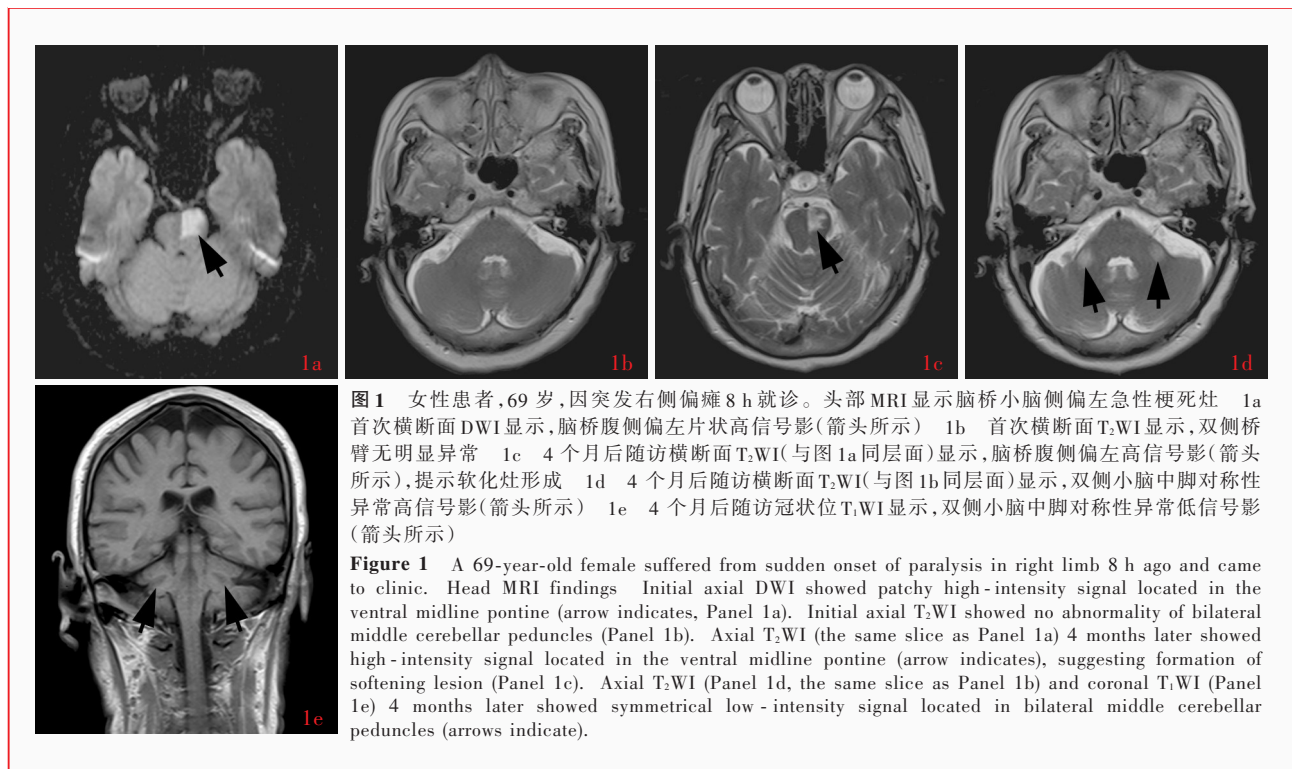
女性患者,69 岁,因突发右侧偏瘫 8 h 就诊。头部 MRI 显示脑桥小脑侧偏左急性梗死灶 1a 首次横断面 DWI 显示,脑桥腹侧偏左片状高信号影(箭头所示) 1b 首次横断面 T₂WI 显示,双侧桥臂无明显异常 1c 4 个月后随访横断面 T₂WI(与图 1a 同层面)显示,脑桥腹侧偏左高信号影(箭头所示),提示软化灶形成 1d 4 个月后随访横断面 T₂WI(与图 1b 同层面)显示,双侧小脑中脚对称性异常高信号影(箭头所示) 1e 4 个月后随访冠状位 T₁WI 显示,双侧小脑中脚对称性异常低信号影(箭头所示)
